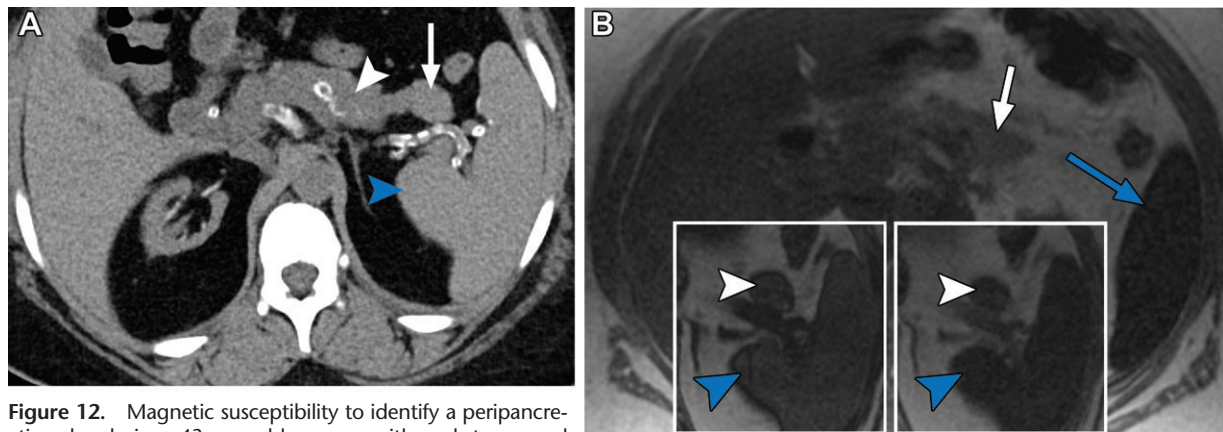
Magnetic susceptibility to identify a peripancreatic splenule in a 43-year-old woman with end-stage renal disease. (A) Axial nonenhanced CT image shows a slightly lobulated mass (arrow) between the pancreas (white arrowhead) and spleen (blue arrowhead). (B) Axial in-phase MR image shows hypointensity of the spleen (blue arrow) relative to the pancreas (white arrow), indicative of splenic iron deposition. The peripancreatic mass (white arrowheads) follows the signal intensity of the spleen (blue arrowheads) when comparing the shorter-TE opposed-phase (left inset) and longer-TE in-phase (right inset) images, consistent with a peripancreatic splenule.
